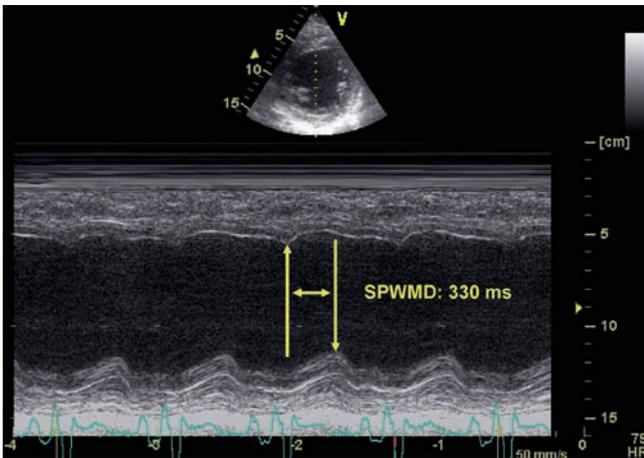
The septal to posterior wall motion delay (SPWMD) measurement by M-mode echocardiography obtained from the short-axis view: a delay of 330 ms indicates significant intra-ventricular dyssynchrony
